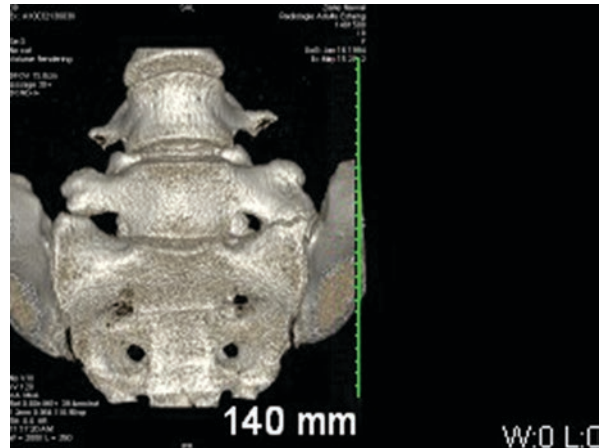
CT scan with 3D reconstruction (sacralization of the fifth lumbar vertebra; left side)
